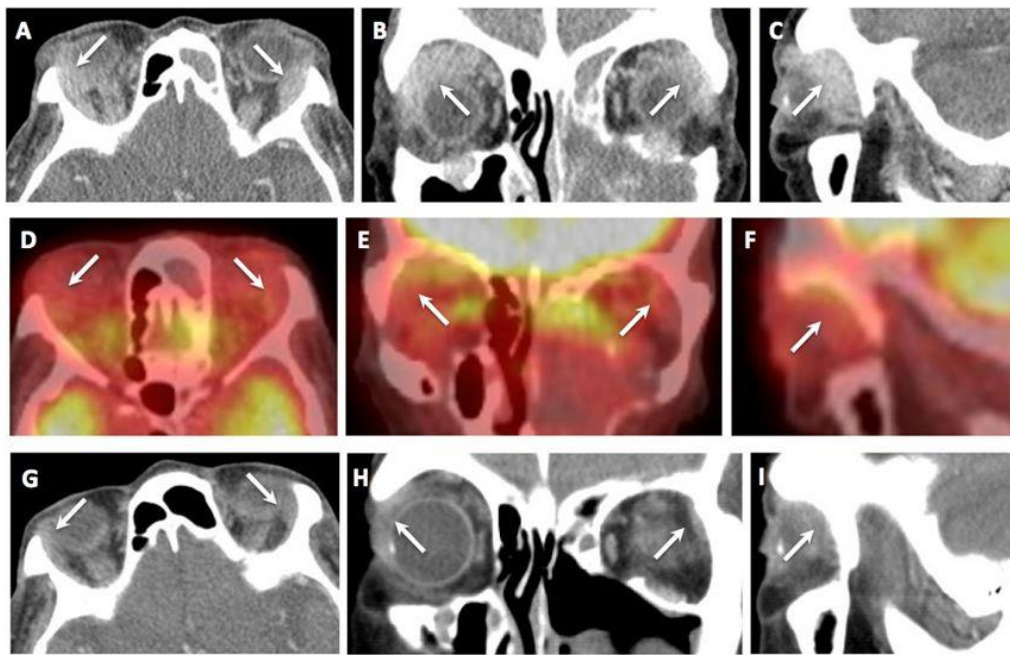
88-year-old male with IgG4-related disease. FINDINGS: Images are axial, coronal, and sagittal from left to right. A-C. A contrast-enhanced CT scan of the head and neck in the venous phase demonstrates bilateral symmetrically enlarged and homogeneous lacrimal glands (arrows). D-F. A concurrent fused PET-CT demonstrates no FDG avidity (arrows). G-I. Three months later, and 7 weeks into steroid treatment, a follow-up contrast-enhanced CT scan of the face in the venous phase demonstrates normalization (arrows). TECHNIQUE: A-C. 64-slice CT, 100-180 mA, 120 kVp, 100 mL Omnipaque 350 IV contrast at 2.5 mL/sec, standard algorithm, 2.5 mm slice thickness. D-F. PET-CT, 18.6 mCi F18-FDG, 1 hour uptake period, multi-bed 3D acquisition, low mA CT attenuation correction (mA 30-65, kVp 140), axial 3.27 mm, coronal 5.47 mm, and sagittal 5.47 mm slice thickness. G-I. 64-slice CT, 150-500 mA, 120 kVp, 100 mL Omnipaque 350 IV contrast at 2.5 mL/sec, standard algorithm, axial 2.5 mm, coronal 5 mm, and sagittal 5 mm slice thickness.
